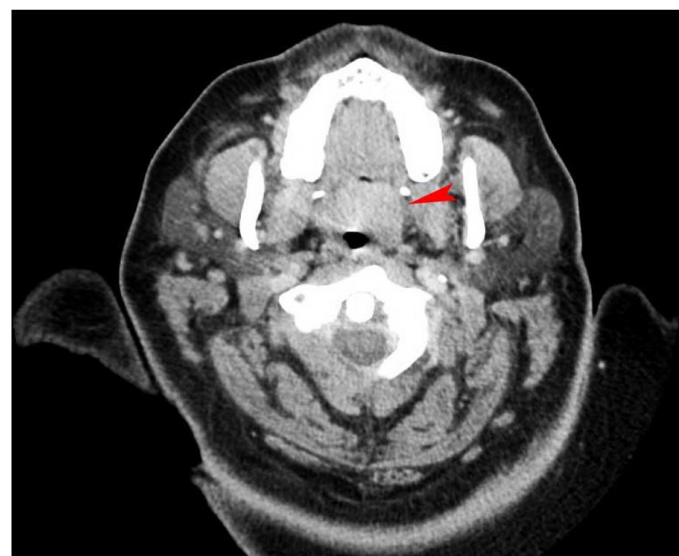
Axial contrast-enhanced CT of the neck demonstrating mildly enhanced mass in the soft palate (red arrowhead).
